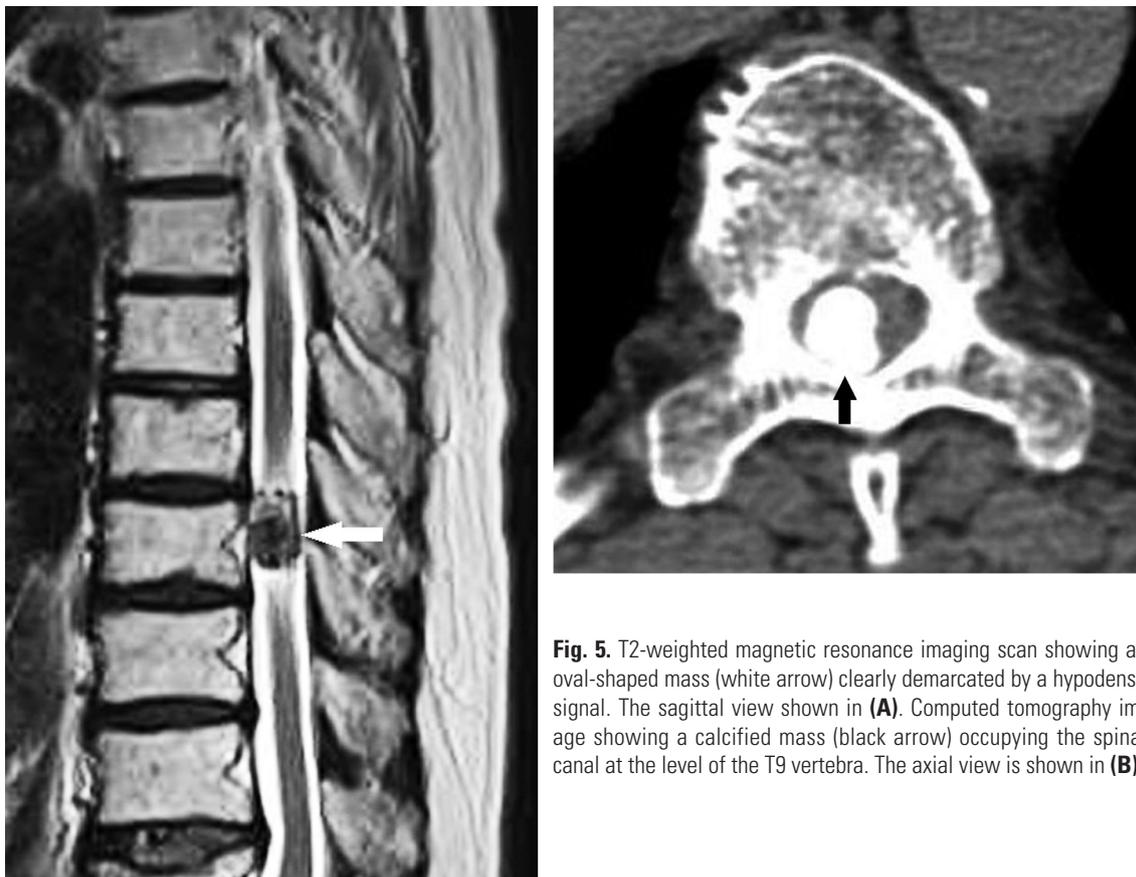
T2-weighted magnetic resonance imaging scan showing an oval-shaped mass (white arrow) clearly demarcated by a hypodense signal. The sagittal view shown in (A). Computed tomography image showing a calcified mass (black arrow) occupying the spinal canal at the level of the T9 vertebra. The axial view is shown in (B).
